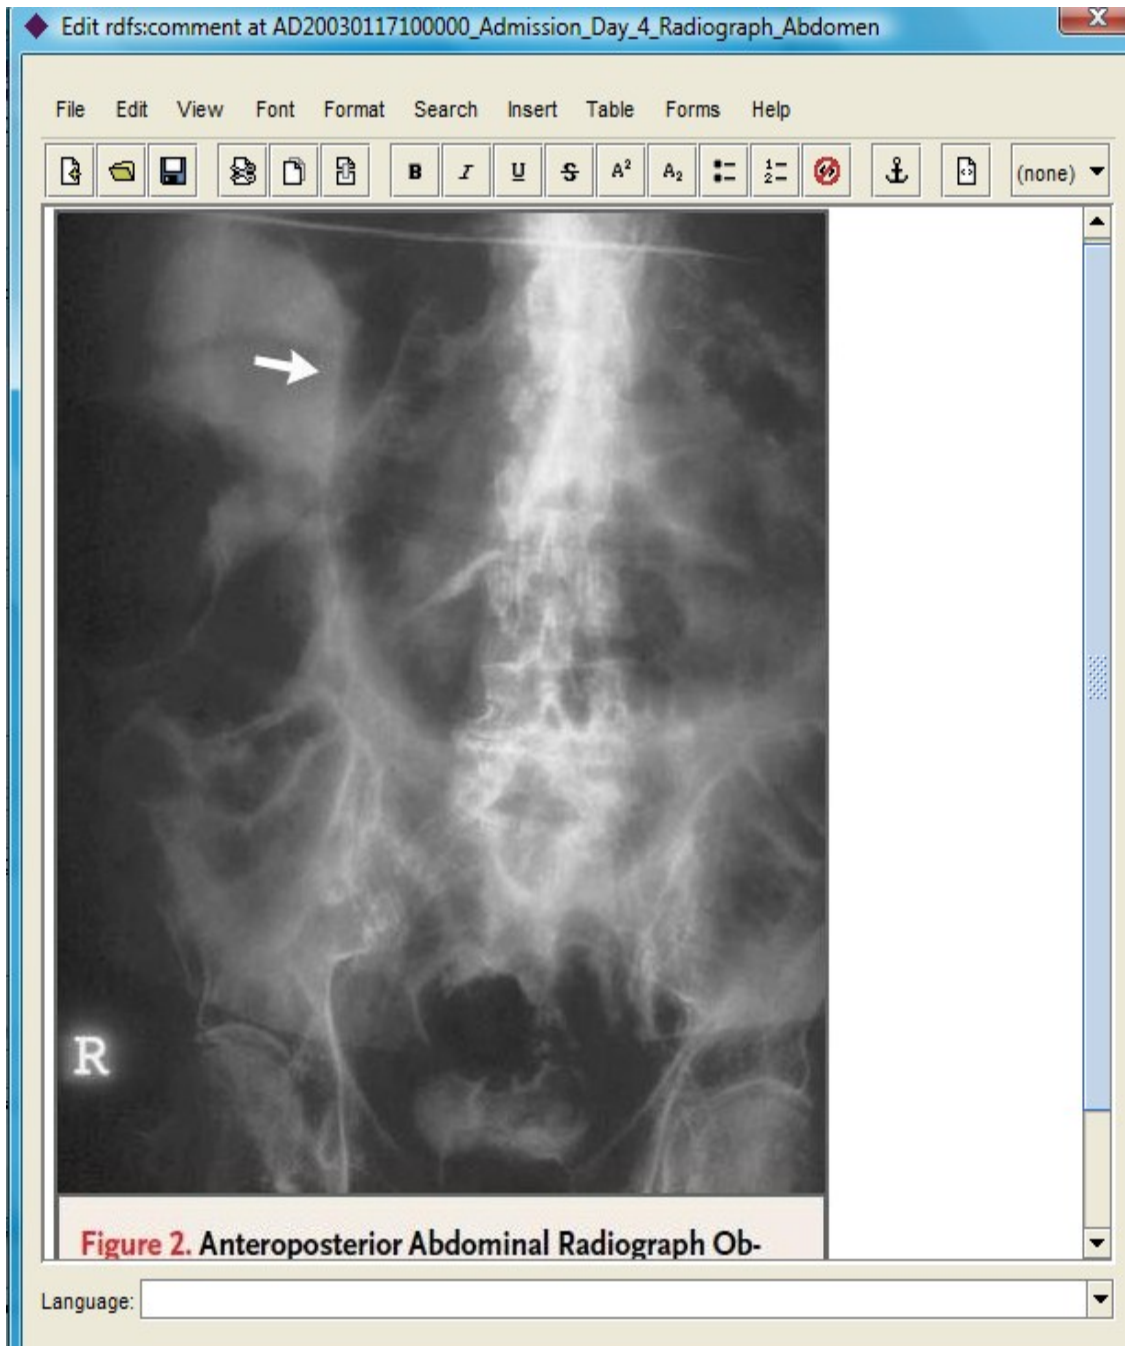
Admission day 4 image of X-Ray Abdomen captured via RDF comment in CD- EMR Ontology.
